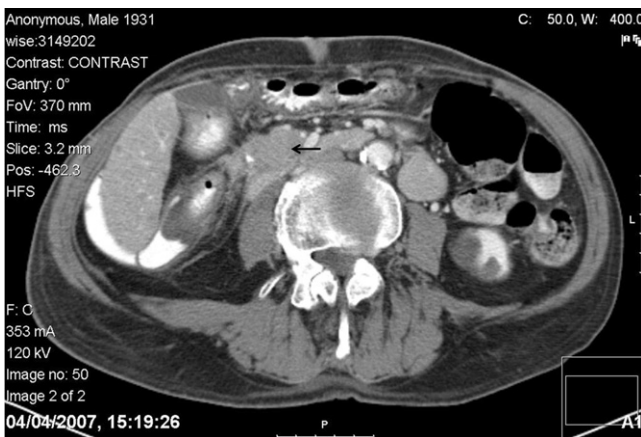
CT abdomen demonstrating an irregular 4 \times 2 cm soft tissue mass within the root of the mesentery in the right iliac fossa closely apposed to the caecum (black closed arrow). The mass contains multiple flecks of coarse calcification and is surrounded by an intense desmoplastic response. These features are highly suggestive of a gastrointestinal neuroendocrine tumour.
